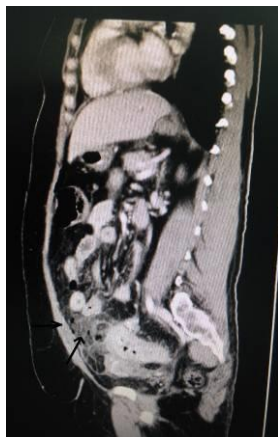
CT of the abdomen and pelvis showing peri-colonic stranding, peri-colonic free air and fluid collection (black arrows)
